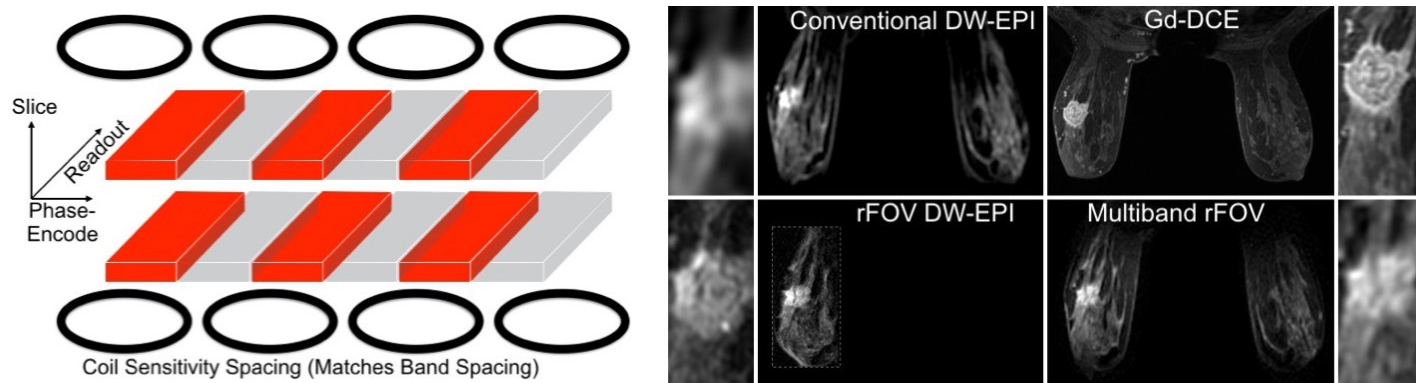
Left: Multiband reduced-FOV excites multiple in-plane bands. The acquired FOV is reduced, to limit distortion, while parallel imaging is used to separate the multiple bands just as in simultaneous multi-slice imaging. Additional bands in another slice can also be excited and resolved with through-slice parallel imaging. Right: Comparison of (counter-clockwise from left) conventional single-shot EPI DWI, reduced-FOV DWI, multiband reduced-FOV DWI, and DCE. The multiband approach offers much better resolution than conventional imaging, but covers the whole slice, unlike reduced FOV. The resolution is much closer to that of DCE than conventional DWI.
